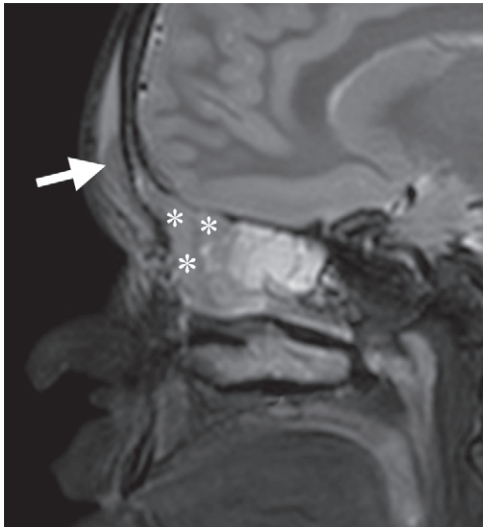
Pott puffy tumor (inflammation from acute frontal rhinosinusitis) in a 10-year-old girl. Sagittal T2W FS MR image shows frontal (*) and ethmoidal sinusitis, T2-hyperintense frontal subgaleal effusion, and a small T2-hypointense subperiosteal abscess (arrow).
